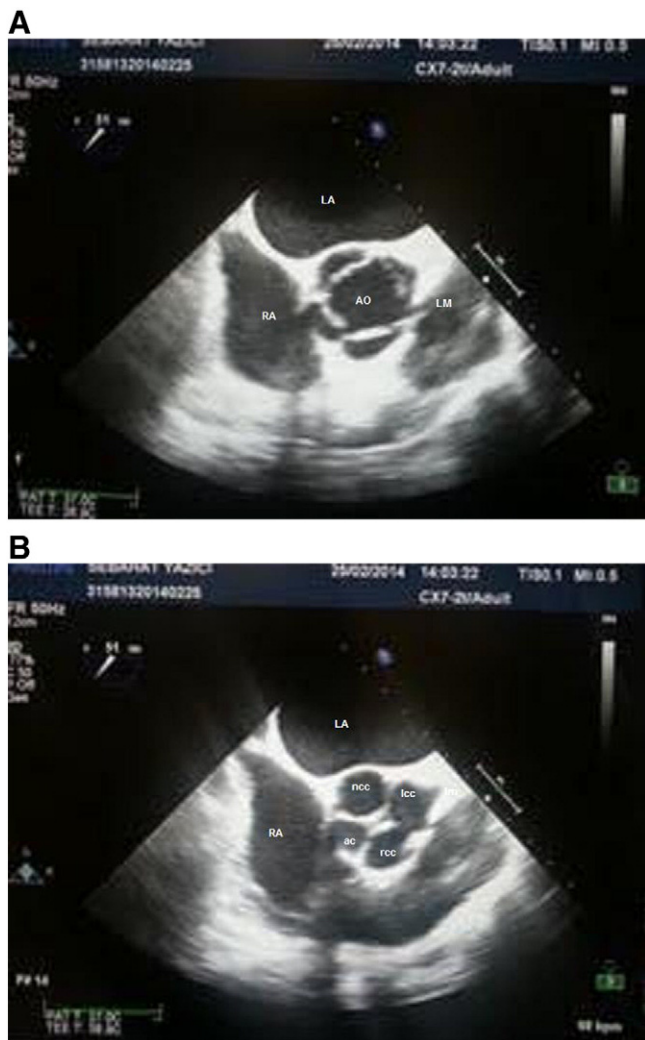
A–B: Two-dimensional transesophageal short-axis view of the aortic valve; showing the quadricuspid aortic valve, which consisted of four equal cusps in both systolic (2a) and diastolic (2b) frames (type A). The “x shaped” commissural pattern in diastole was confirmed (2b). The left main coronary artery (LM in B) was detected in the normal position. ac – accessory cusp; lcc – left coronary cusp; ncc – non-coronary cusp; rcc – right coronary cusp; AO – aorta; LA – left atrium; LV – left ventricle; RA – right atrium; RV – right ventricle; LM – left main.
